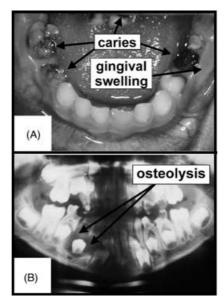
Severe caries presented in patient eight providing an ecologic niche for *Candida albi-cans* able to release planktonic counterparts. (A) Photograph showing caries and gingival swelling. (B) Radiograph showing osteolyses.
